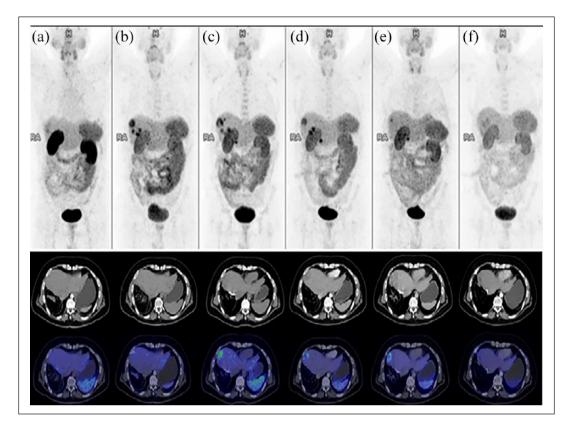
68Ga-DOTA-E-[c(RGDfK)]2 PET/CT scan: (a) baseline PET/CT in maximum intensity projection (MIP; upper) and PET/CT fusion axial slices (lower) demonstrate normal biodistribution of the radiotracer and residual liver disease post hepatectomy; (b) after 3 months, PET/CT showed new hepatic lesions and progression of disease was documented; (c) after 6 months of the same therapy, a new hepatic lesion was seen; (d) 4 months later, the same lesions was seen and stable disease was documented; (e) 5 months after changing the therapy, morphologic lesions decreased and also molecular uptake of lesions and partial response was documented; (f) the last PET/CT showed a decrease of the lesions with a little uptake.
